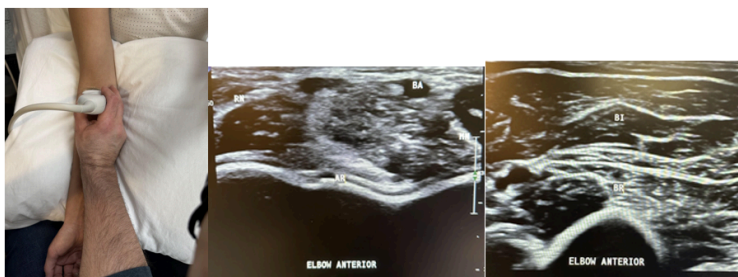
Side-by-side pictures of the transducer position on the elbow and anterior transverse elbow imaging of the anterior recess (AR), radial nerve (RN), brachial artery (BA), median nerve (MN), biceps (BI), and brachialis (BR) just proximal to the elbow crease. The abbreviations given here and labeled on the ultrasound images represent the corresponding structures.
